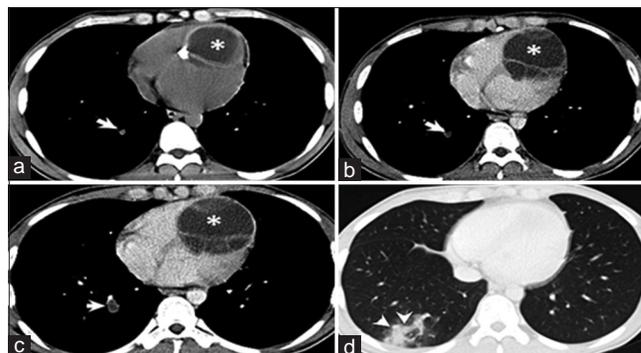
Contrast-enhanced CT examination shows mural calcification in right ventricle apical region adjacent to the membranous portion of interventricular septum and 1/2 position of muscular septum in pre-contrast images (a) contrast enhanced internal septations and cystic wall (b, c) multilocular cystic lesion (asterisk). Bronchial expansion of right lower lobe and cystic appearance suggesting pulmonary spread of HC (a-c) (Thick arrow). Ground glass and consolidation-like density in the right lower lobe posterior-basal segment which was the watershed zone of the related pulmonary artery suggesting inflammation or infarction (d) (arrowhead)
